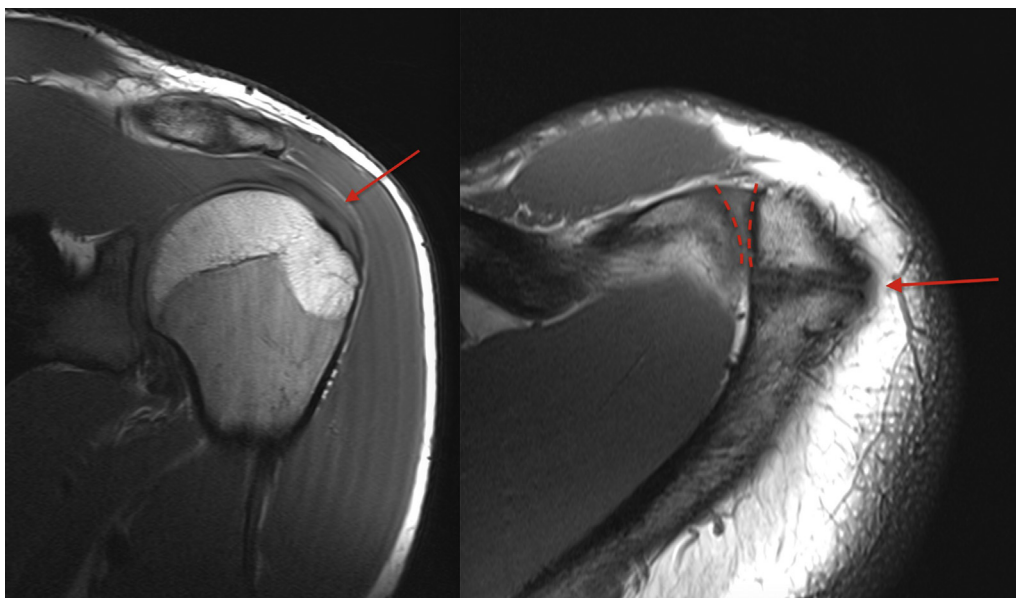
(Left) T1-weighted MRI coronal view of a left shoulder shows intact supraspinatus insertion. (Right) T1-weighted MRI axial view of a left shoulder shows the os mesoacromiale joint line (→) The adjacent acromioclavicular joint remains free of arthritic changes (- - -). MRI, magnetic resonance imaging.
